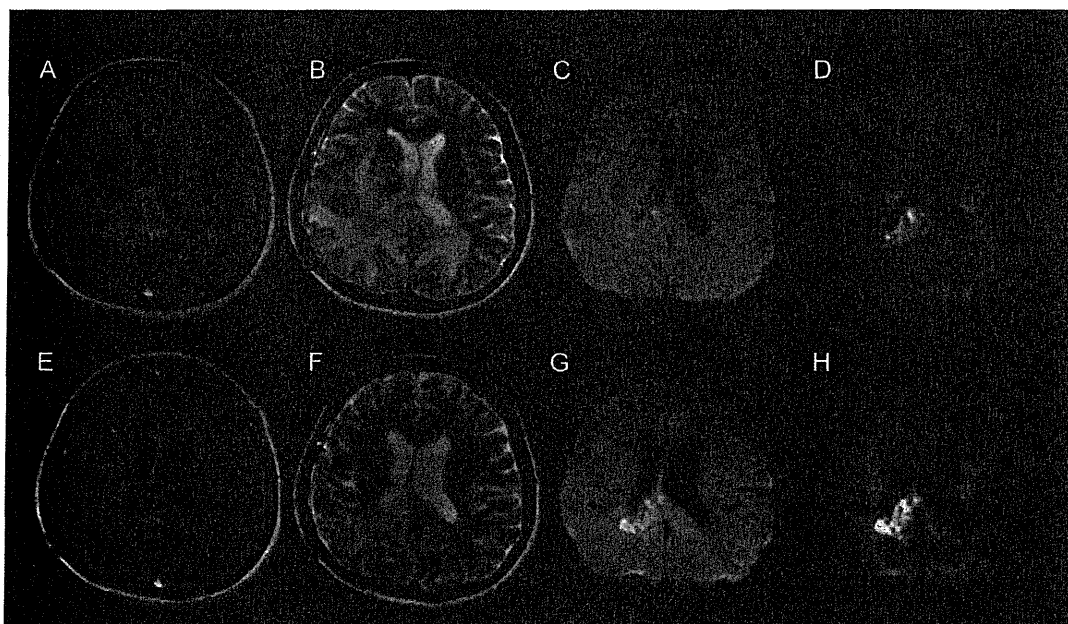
This 42-year-old woman with glioblastoma underwent radical surgery and radiotherapy with concomitant and adjuvant chemotherapy with temozolomide. Gd-enhanced T1-weighted- (A) and T2-weighted images (B) and DWI_{1000} (C) and DWI_{4000} (D) were acquired before bevacizumab treatment. Gd-enhanced T1-weighted images showed a marked decrease in the enhanced lesion (E). On T2-weighted images we noted a marked decrease in the high intensity area, a decrease in the mass effect, and improvement in the midline shift (F). DWI_{1000} showed an increase in the high intensity area (G). On DWI_{4000} there was an obvious increase in the high-intensity area (H). She died of tumor recurrence 3 months after first course of bevacizumab.
